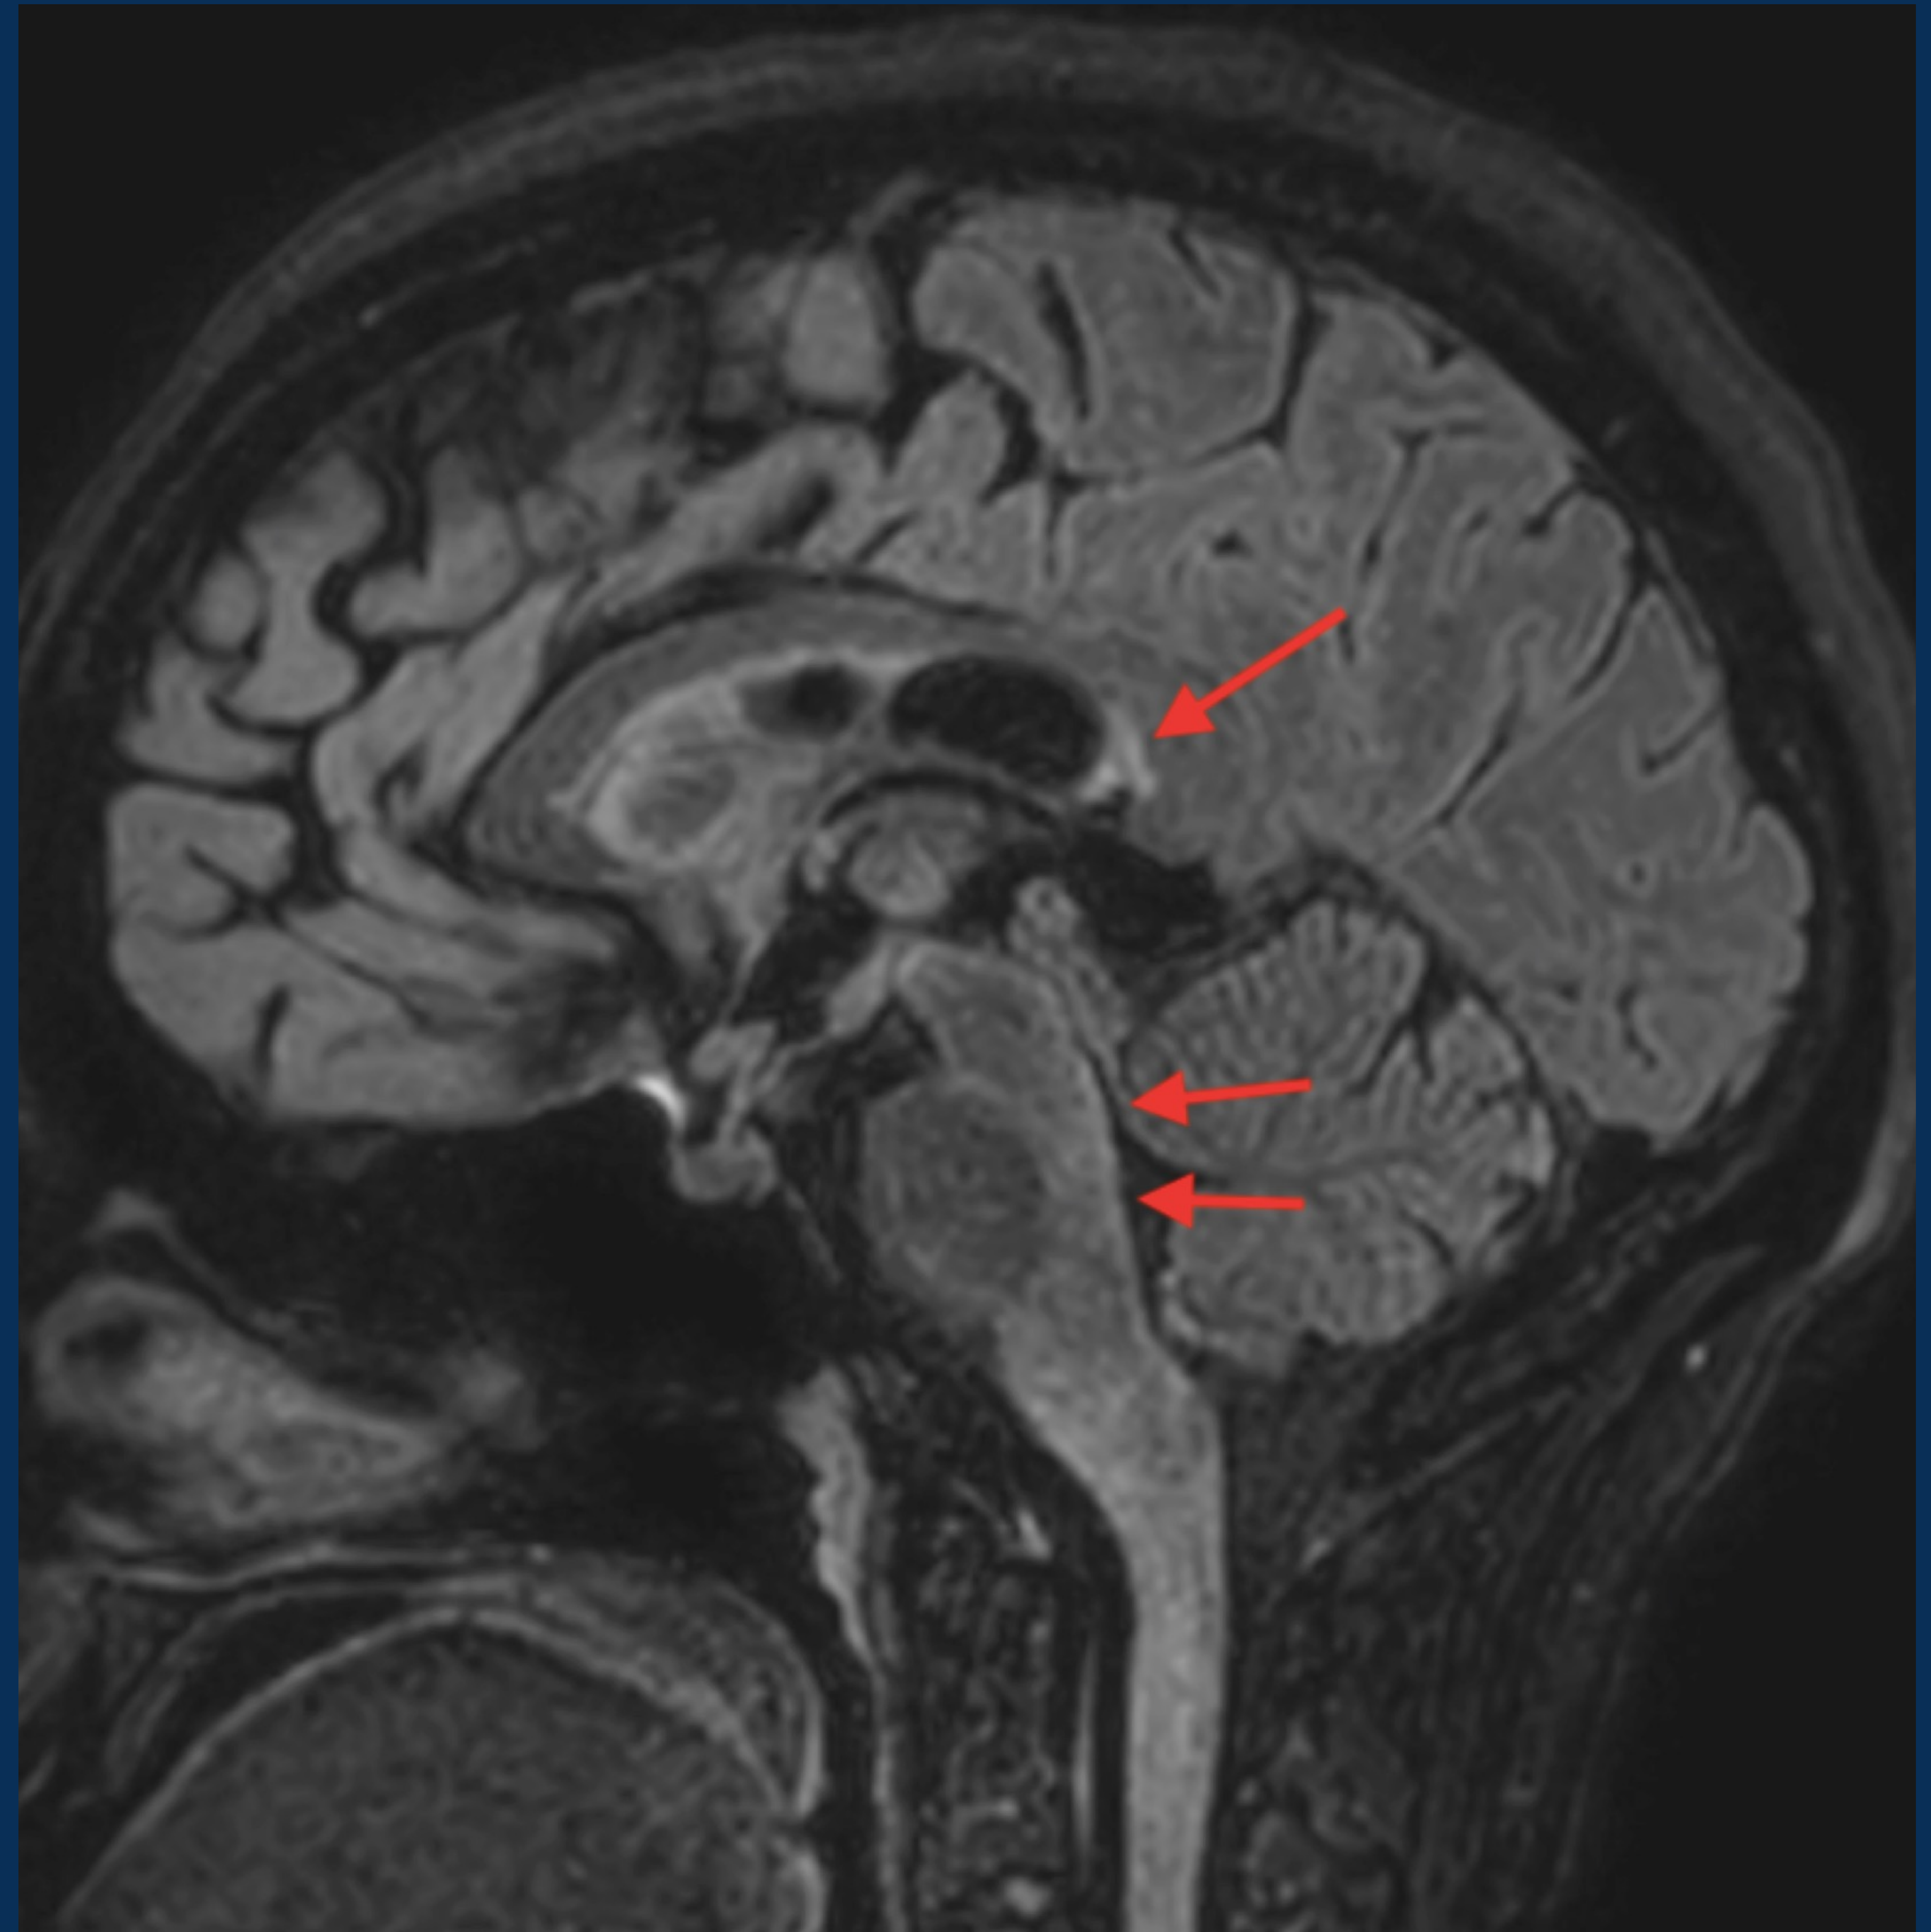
Sagittal T2 FLAIR of head with hyperintense lesions on second presentation (arrows).
